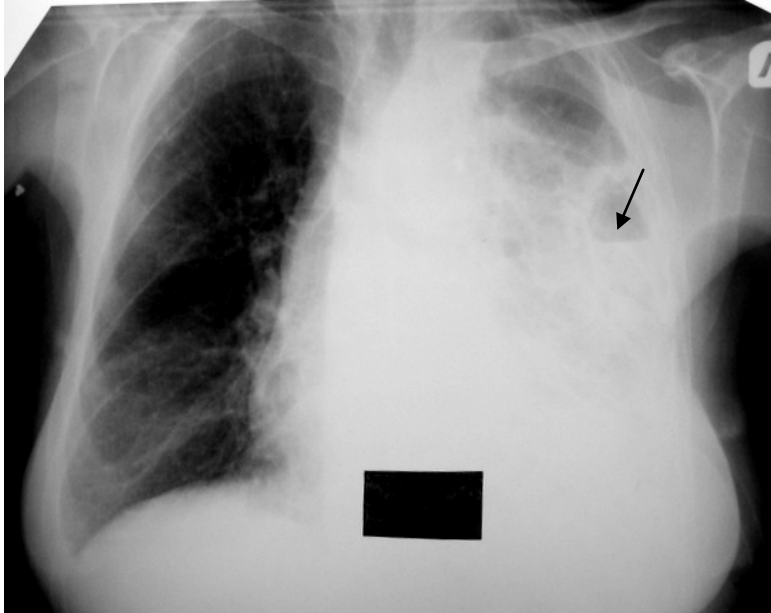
The frontal chest radiograph. The total non-uniform shadow in the left pulmonary field, in the top department of average intensity with an indistinct contour, in the bottom department with high intensity, on this background is available a hyperlucency (arrow) with horizontal level (a disintegration cavity). The dome of a diaphragm and sine at the left are not differentiated. Mediastinum it is displaced to the right. A staphylococcal pneumonia of left lung. Pleural effusion in the left side
